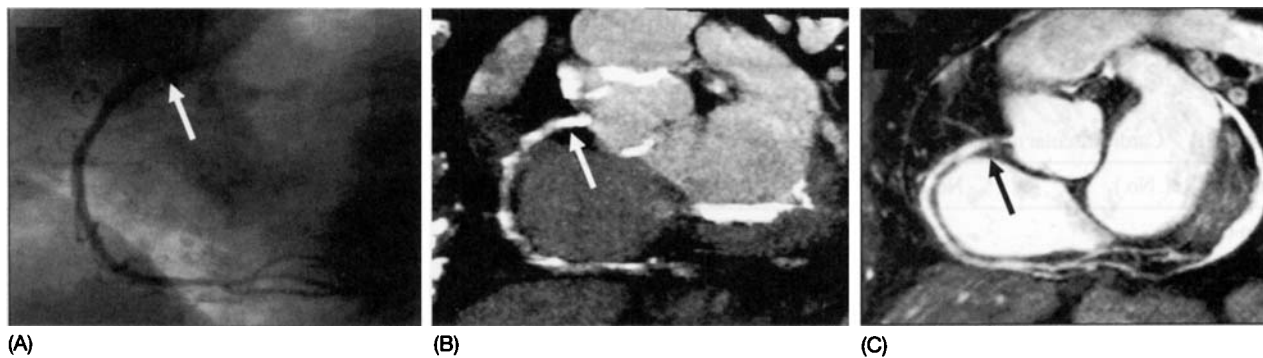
Right coronary artery (RCA) (A) projection x-ray angiogram, (B) 16-slice multidetector computed tomography (CT), and (C) coronary cardiovascular magnetic resonance (CMR) in a patient with prominent epicardial calcium. Note the ostial RCA stenosis (arrows) is visible on the x-ray angiogram and the coronary CMR, but not on the multidetector CT because of extensive calcium. Courtesy of Dr. David Maintz.
